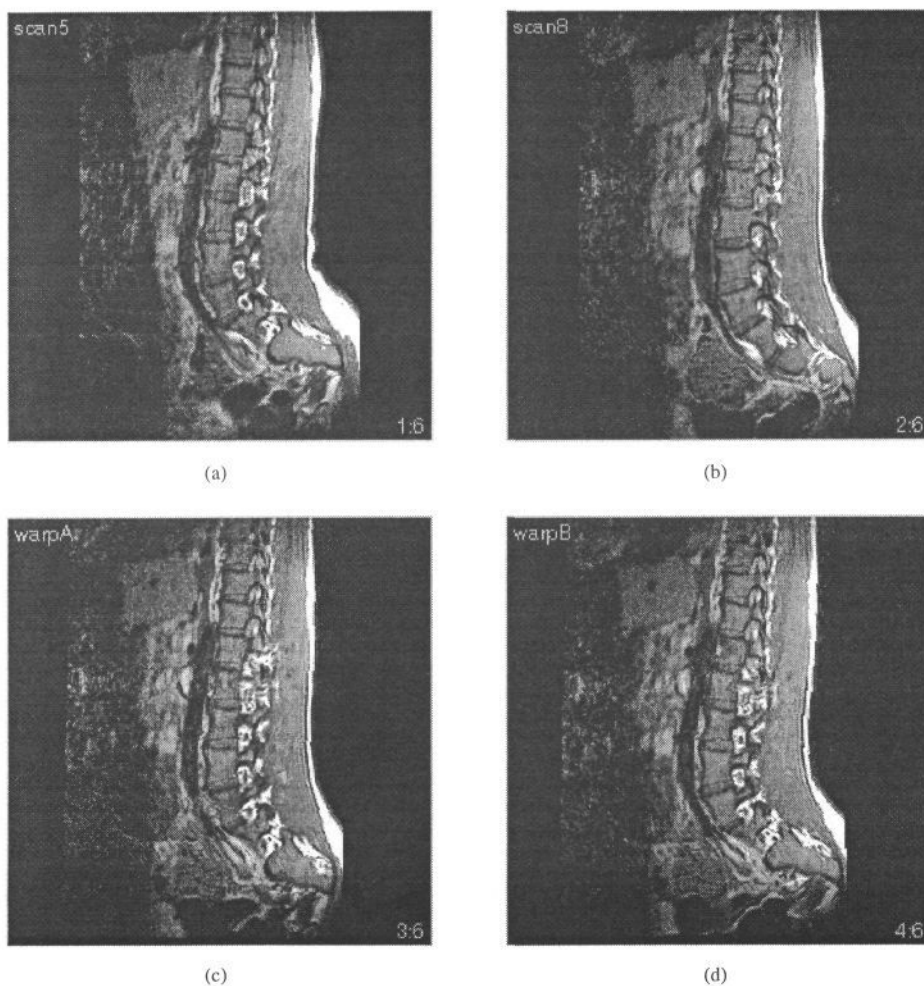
Comparison of rigid body and 3D warping on a MR image of the spine, (a) Original MR image, (b) New MR image after movement, (c) the result of transforming (b) to (a) using rigid body transformation and (d) the result of transforming (b) to (a) using 3D warping. Warping provided a more accurate estimate of the position of the lumbar spine and abdominal aorta.
